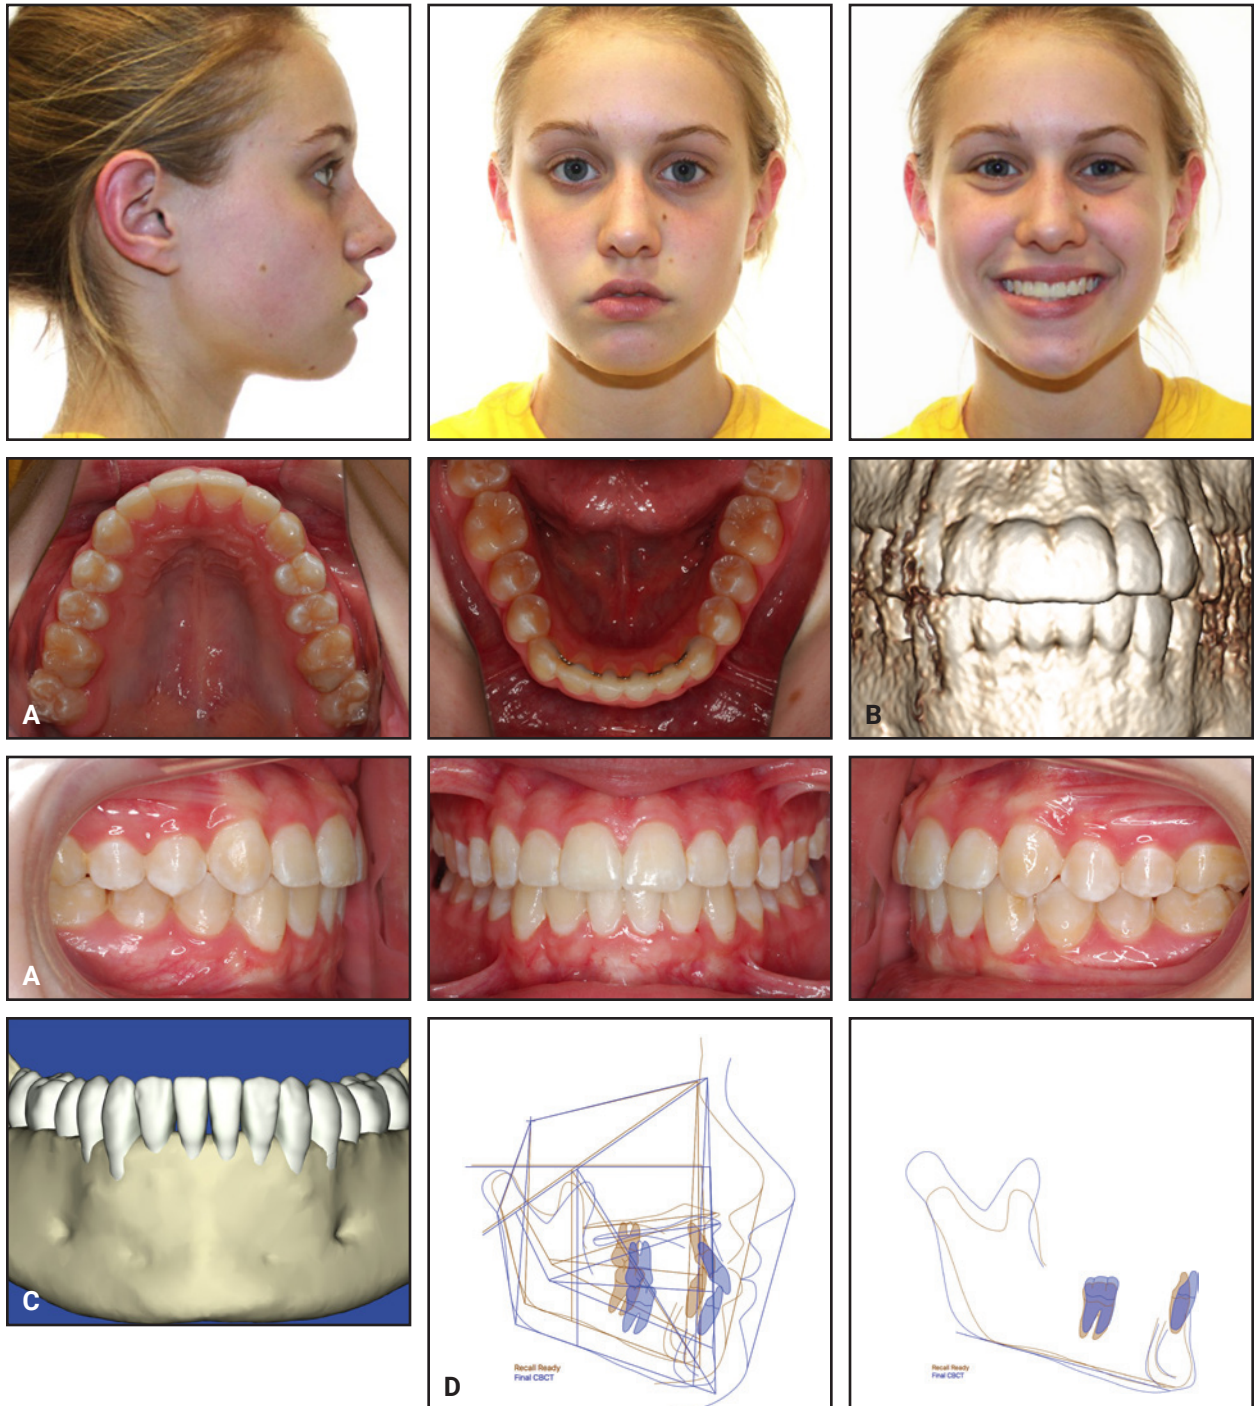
Case 1. A. Patient after 15 months of orthodontic treatment. B. Cone-beam computed tomography (CBCT) image. C. Final SureSmile* scan (taken 21 months after treatment), documenting retention of grafted bone. D. Superimposition of pre- and post-treatment cephalometric tracings.
